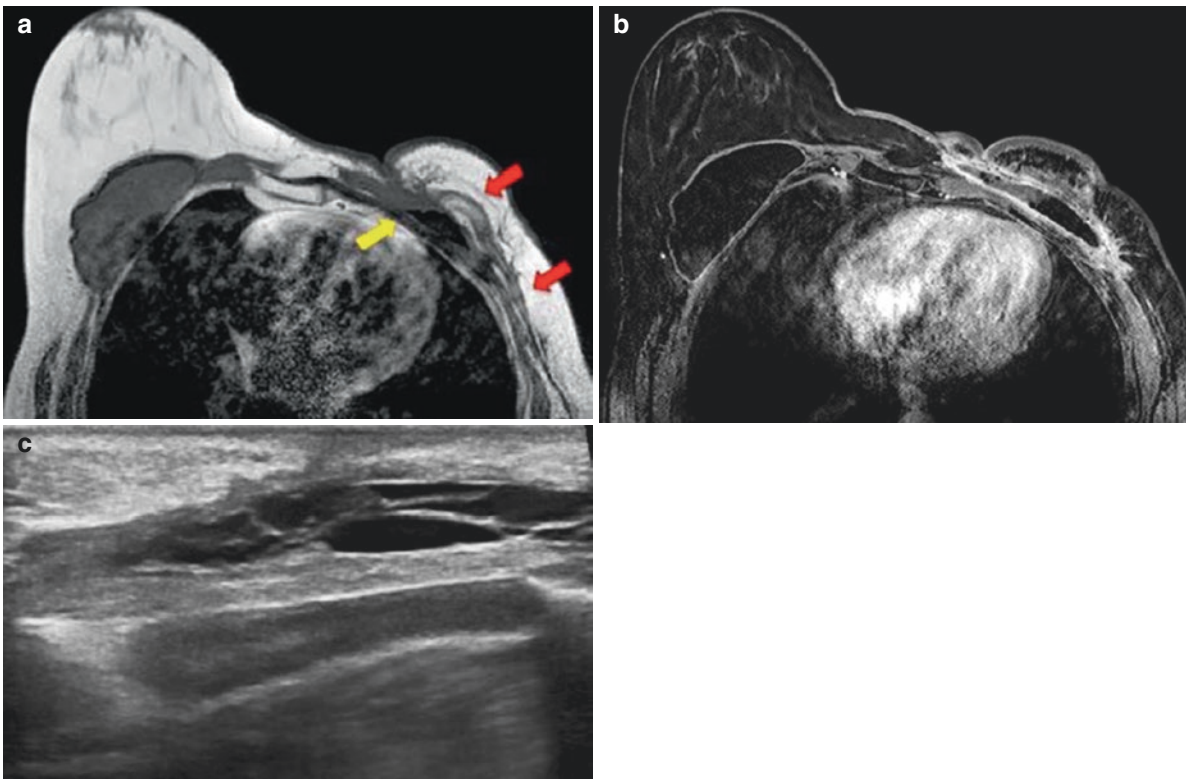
Patient with left mastectomy and failed autologous reconstruction with LDM flap and implant. Due to recurrent peri-prosthetic infection, the implant was eventually removed but the transferred LD stayed. (a) Breast MRI with T1 sequences shows the LDM flap (*red arrow*) coming from the back and located anteriorly to the pectoral
